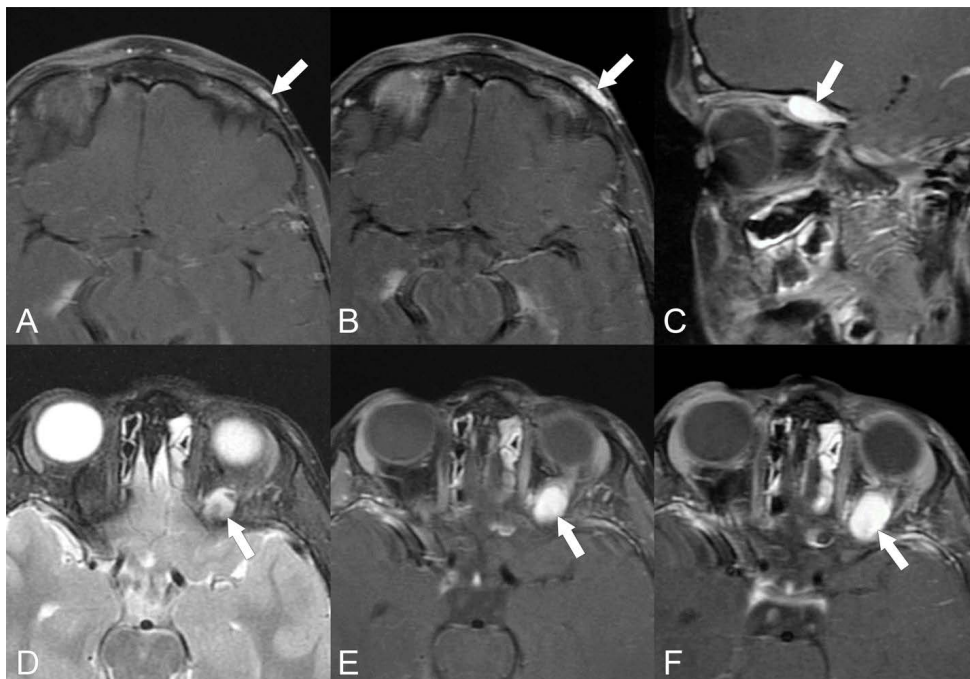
MRI of the 5-year-old male shows dilation of the left forehead lesion and an incidental left extraconal mass between the supine (A, C-E) and right lateral decubitus positions (B and F). (A), Axial T1 post-contrast MRI, supine position shows the enhancing left forehead subcutaneous soft tissue mass (arrow). (B), T1 post-contrast MRI, right lateral decubitus position shows homogeneous enhancement and enlargement of the left brow mass consistent with a varix (arrow). (C), Sagittal T1 post-contrast MRI, supine position shows an incidental homogeneously enhancing extraconal mass (arrow). (D), Axial T2 MRI, supine position, shows a hyperintense appearance of the incidental extraconal mass. (E), Axial T1 post-contrast MRI, supine position shows homogeneous enhancement of the mass (arrow). (F), T1 post-contrast MRI, right lateral decubitus position shows enlargement of the homogeneously enhancing extraconal mass consistent with a varix (arrow).
